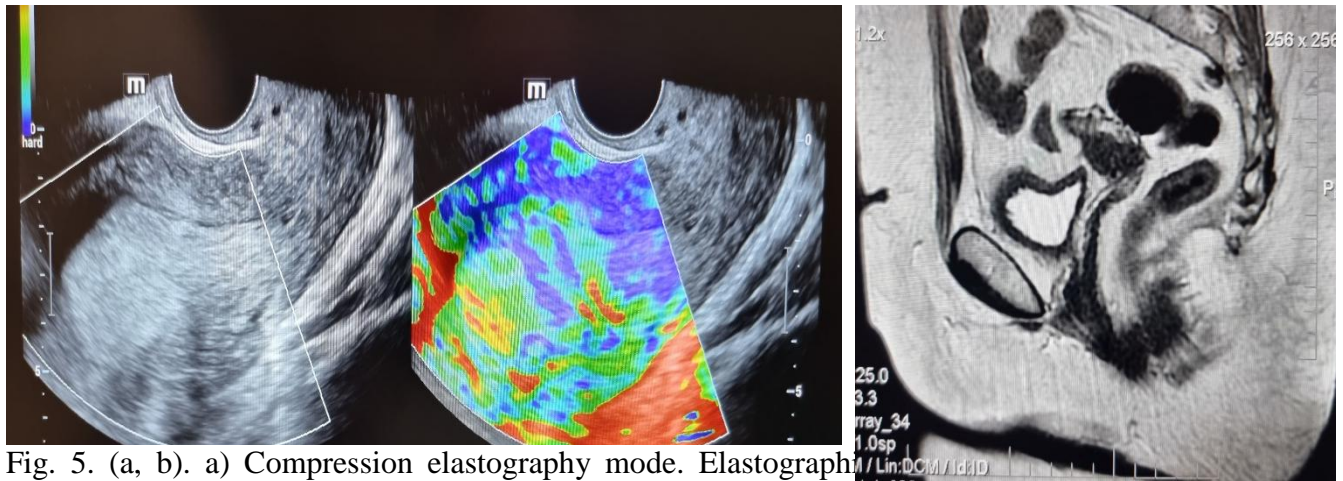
(a, b). a) Compression elastography mode. Elastography in patients with endometrial hyperplasia. Alternating shades of green and yellow are noted b) MRI study
